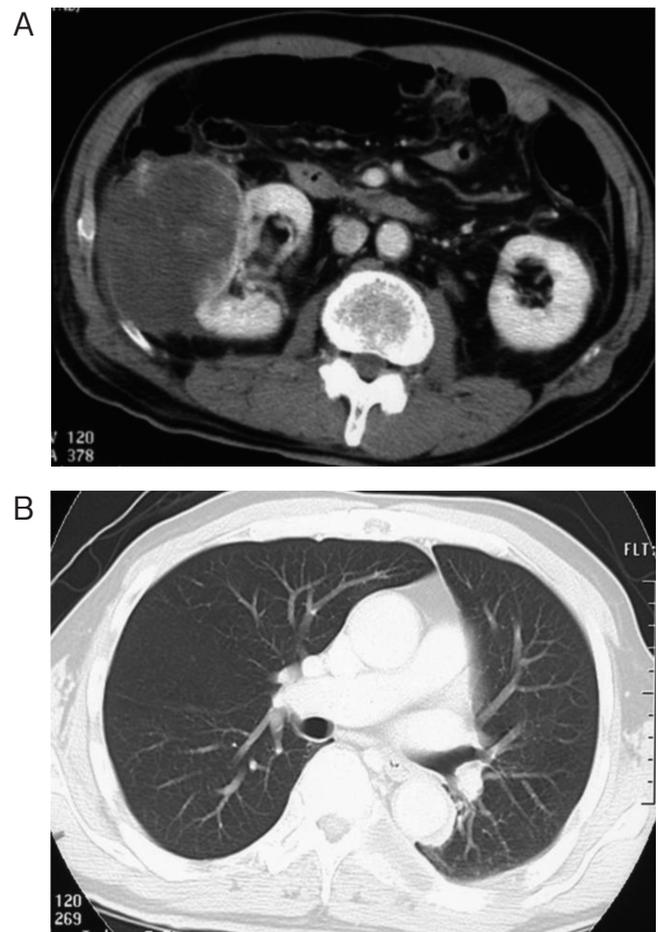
(A, B). Abdominal CT after 4 cycles of sunitinib showing 28.5% tumor reduction according to RECIST criteria (A) and lung metastasis had disappeared (B).
